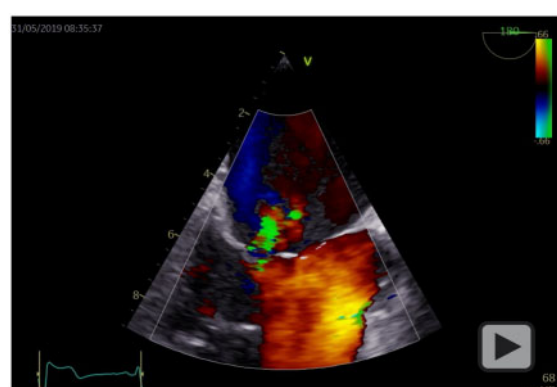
(A) Diagnostic transoesophageal echocardiography revealed severe aortic valve and mitral valve infective endocarditis as well as aortic root abscess. (B) Transoesophageal echocardiography before discharge showed no pendulous excrescences. (C, D) Control transoesophageal echocardiography 4 weeks after discharge showed severe valve excrescences, aortic annular aneurysm, and loosening of the mitral valve prosthesis.
